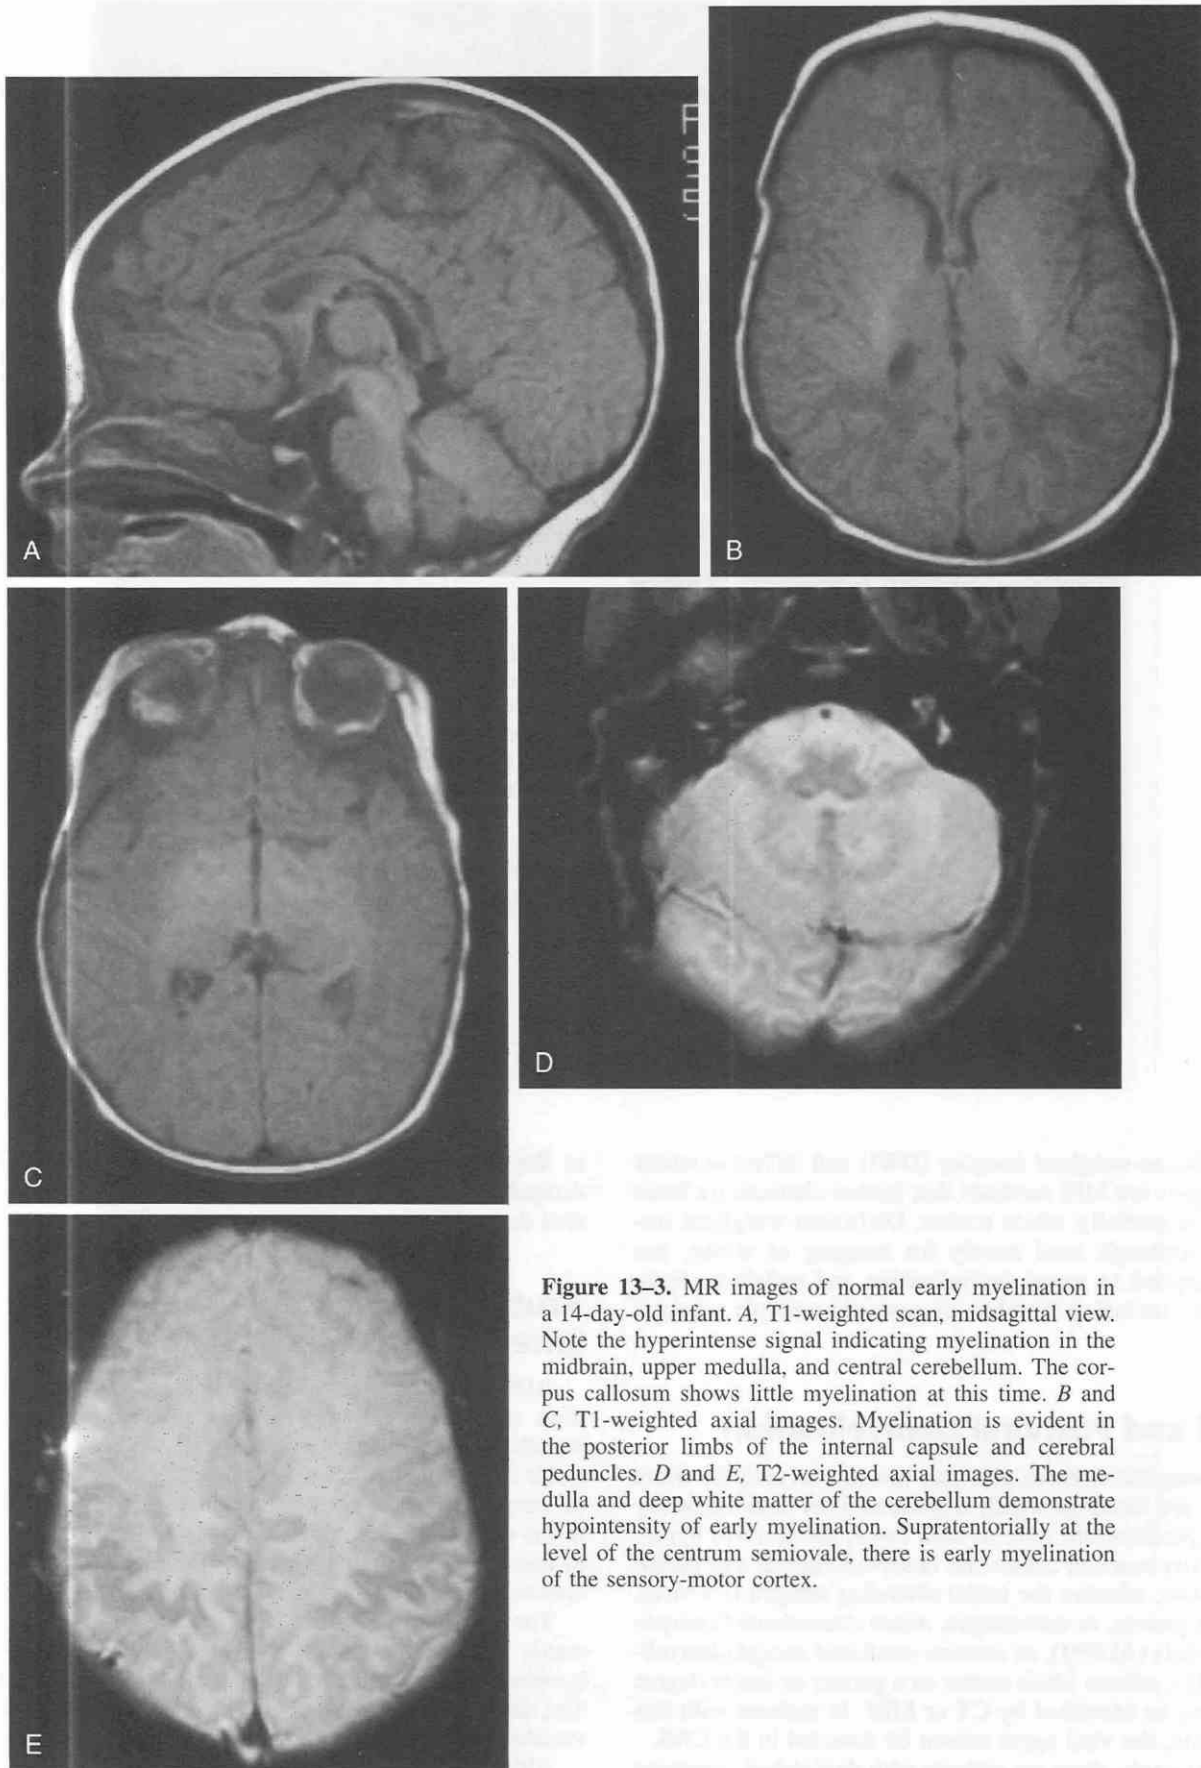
MR images of normal early myelination in a 14-day-old infant. *A*, T1-weighted scan, midsagittal view. Note the hyperintense signal indicating myelination in the midbrain, upper medulla, and central cerebellum. The corpus callosum shows little myelination at this time. *B* and *C*, T1-weighted axial images. Myelination is evident in the posterior limbs of the internal capsule and cerebral peduncles. *D* and *E*, T2-weighted axial images. The medulla and deep white matter of the cerebellum demonstrate hypointensity of early myelination. Supratentorially at the level of the centrum semiovale, there is early myelination of the sensory-motor cortex.
